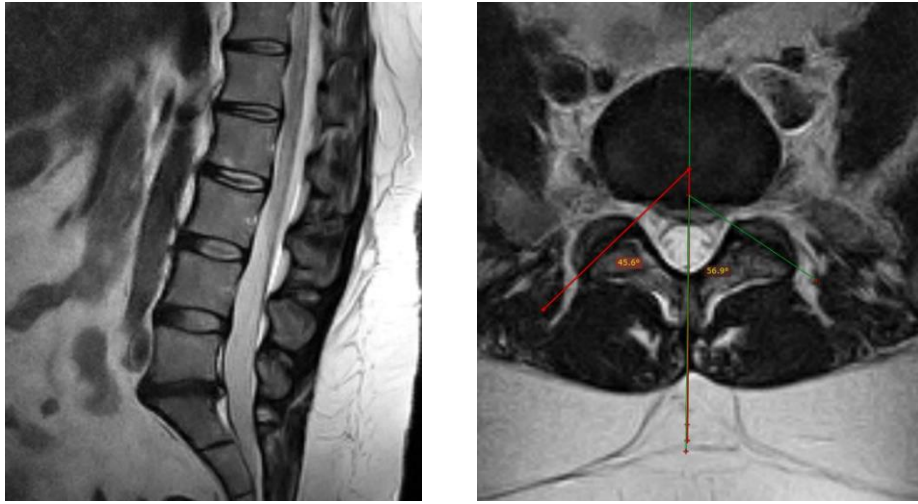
Preoperative MRI Scan
